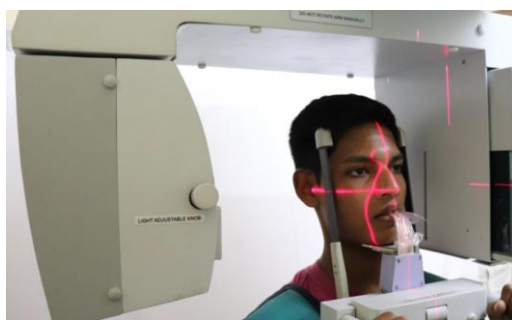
Allengers Smart Pan (2K15030009-D9) panoramic radiographs machine
